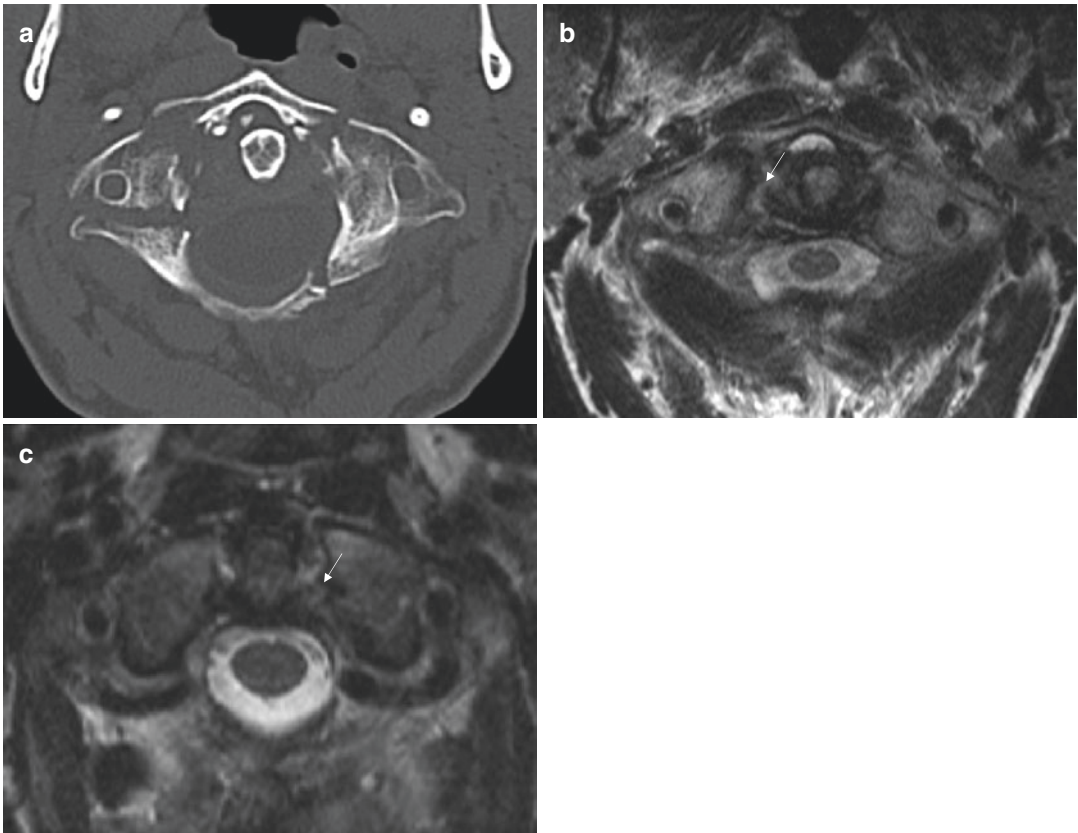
(a) Axial CT image demonstrates four part C1 fracture with displaced lateral masses. (b) Axial T2-weighted image demonstrates focal full thickness discontinuity at the right C1 attachment of the transverse ligament compatible
